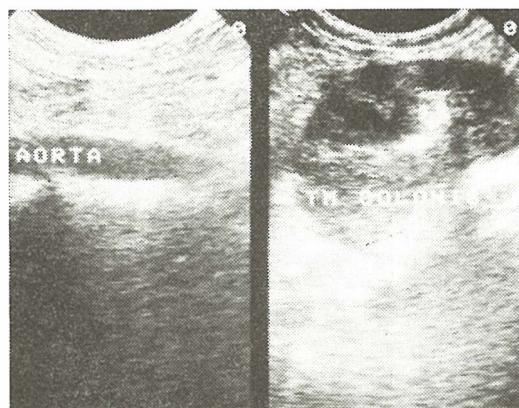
Sonographic scan of stenotic cancer of the ascending colon
